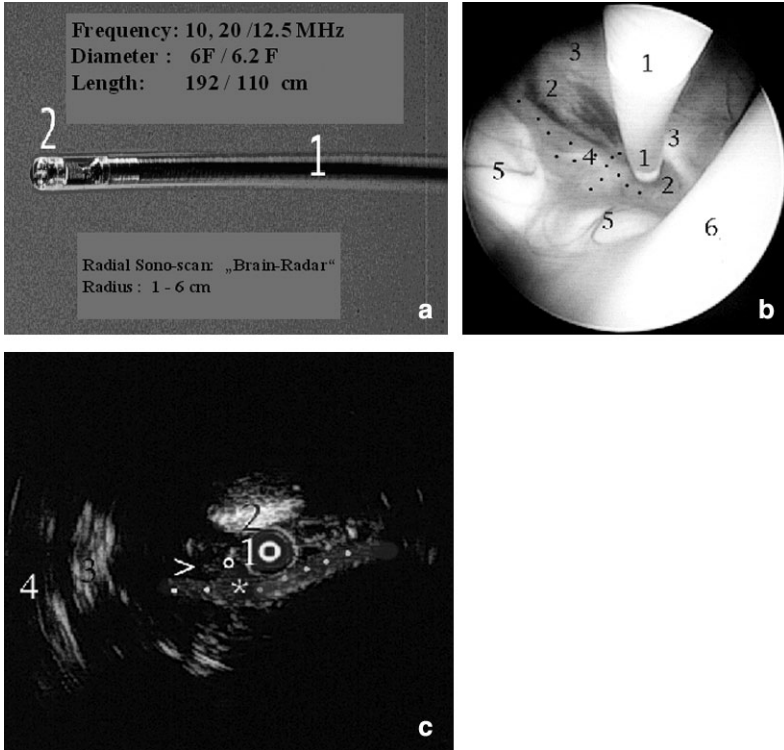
(a) Probe for endosonography (1 Sono-catheter, 2 Sono-Mini-Probe). (b) anatomic view of the third ventricle during neuroendosonography (1 Sono-Mini-Probe, 2 Cinereum (preammillar membrane), 3 Dorsum of Sellae, 4 Basilar Head (beneath floor of 3. ventricle), 5 Mammillary Bodies, 6 Hypothalamus. (c) 1 Sono-Mini-Probe, 2 Dorsum of Sellae, 3 Oculomotor Nerve, 4 Tentorial Notch, * Basilar Artery, . . Right and Left PI
